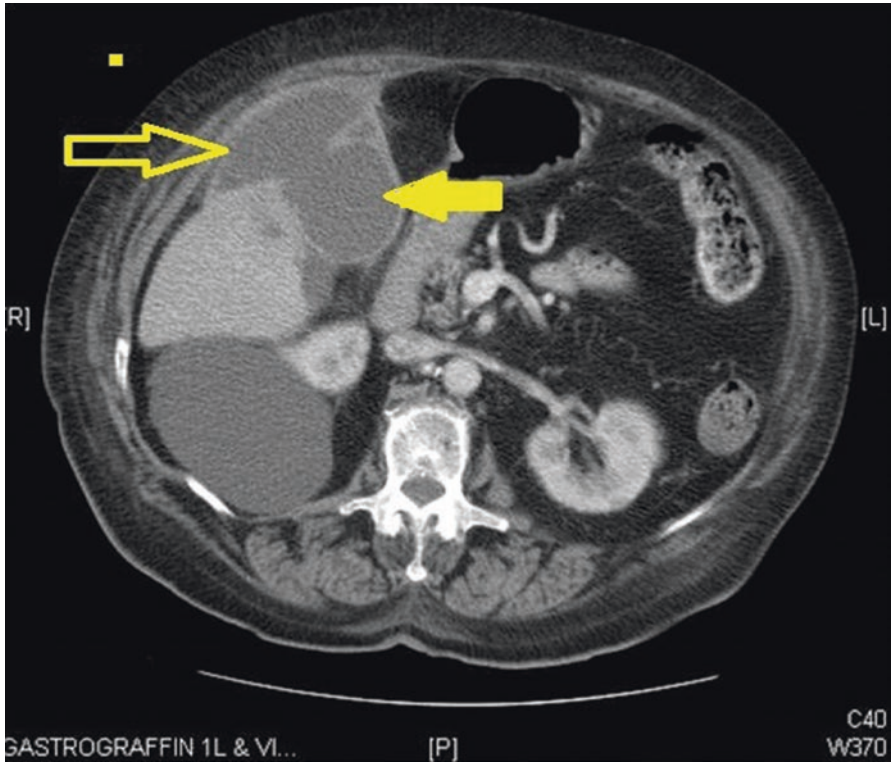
CT scan in a 72-year-old woman who presented with 6 days of upper abdominal pain, fevers and night sweats. The CT revealed an inflamed gallbladder (solid arrow) with an obvious defect in the fundus and a large contained collection (outlined arrow). At operation this was a walled-off perforation. It had been walled off predominantly between the omentum, abdominal wall and liver
